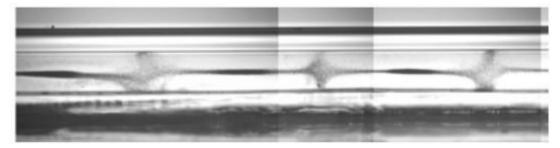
Cross section of 300 μm wide square capillary showing vertical confinement within the fundamental mode of the capillary. Due to end effects of the capillary and the finite length of the ultrasound transducer there are periodic zones with poor lateral/vertical confinement, as seen by the dispersion of 1 μm silica spheres.
